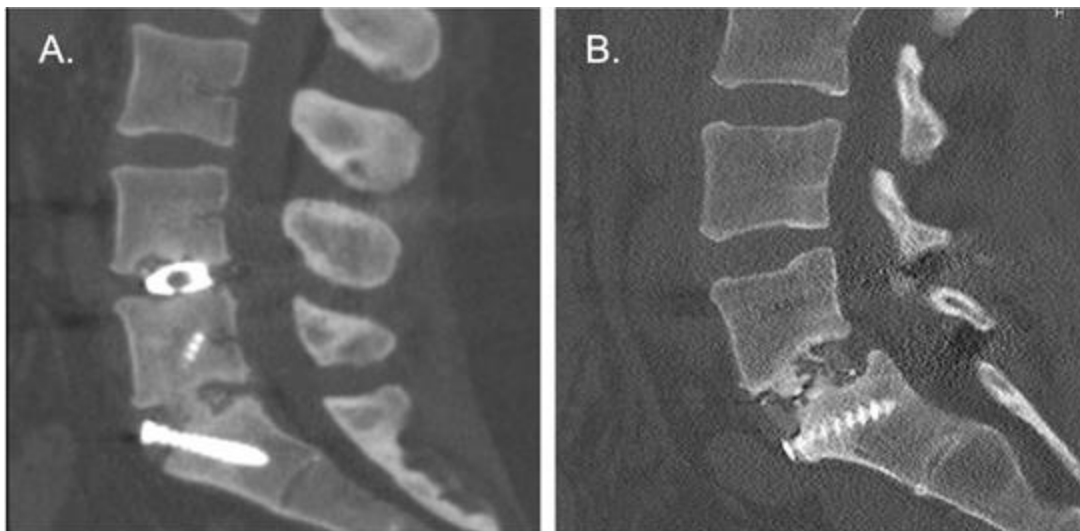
Radiographic images showing fusion status at 24 months. (A) Fusion success. (B) Fusion failure.
